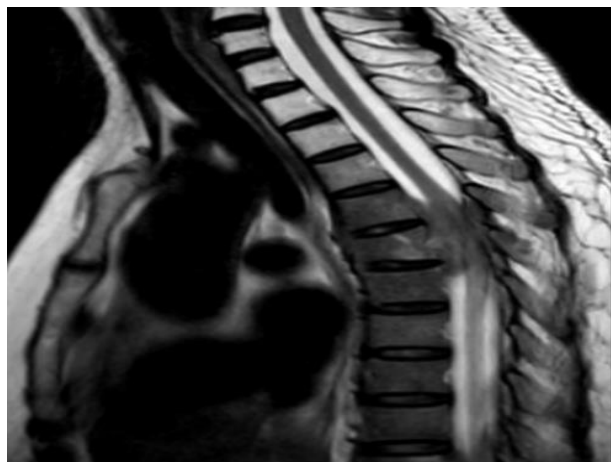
T1 weighted MRI saggital view.
